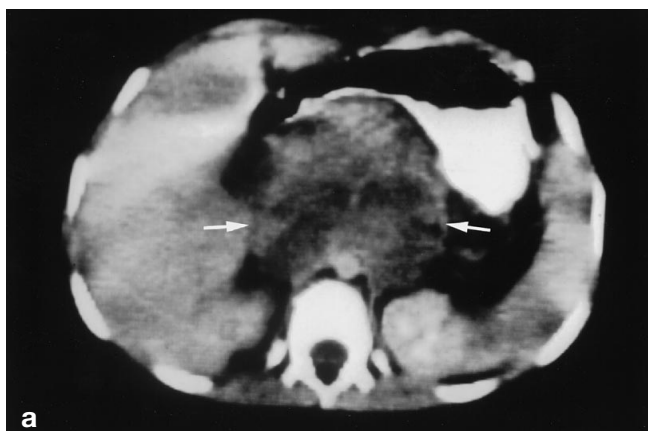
Case 2. Enhanced CT scans through upper abdomen at ages 8, 13, and 14. a Age 8. Heterogeneous retroperitoneal ganglioneuroma anterior to the aorta (arrows) that causes anterior displacement of the pancreas and stomach. The mass had remained stable on sonography for more than 7 years. b Age 13. Interval increase in size of the retroperitoneal mass (cursors) due to the development of a malignant peripheral nerve-sheath tumor. Note the rounded low-attenuated area anteriorly within the mass (arrow). c Age 14. Further increase in size of the retroperitoneal mass, particularly of the low-attenuated anterior component (white arrows), which on pathology proved to be due to tumoral necrosis and dilated entrapped pancreatic ducts
